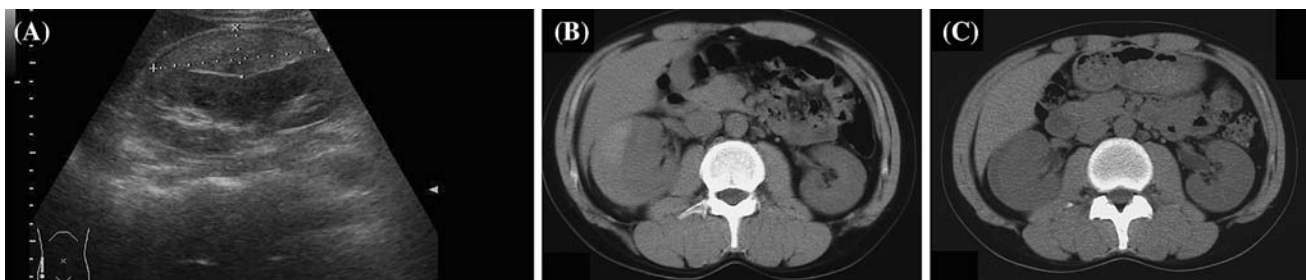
U/S of the right kidney showing a subcapsular hematoma (a); CT section of the kidney showing the subcapsular hematoma (b); CT obtained 2 months after admission shows a decreased hematoma size (c)
